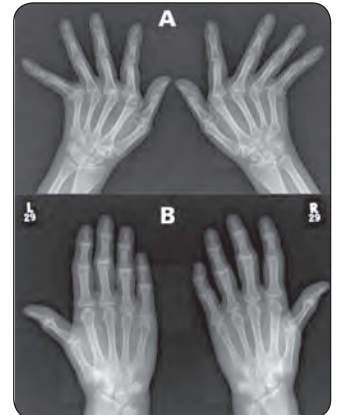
Rheumatoid arthritis (A) compared with osteoarthritis (B) changes on X-ray
